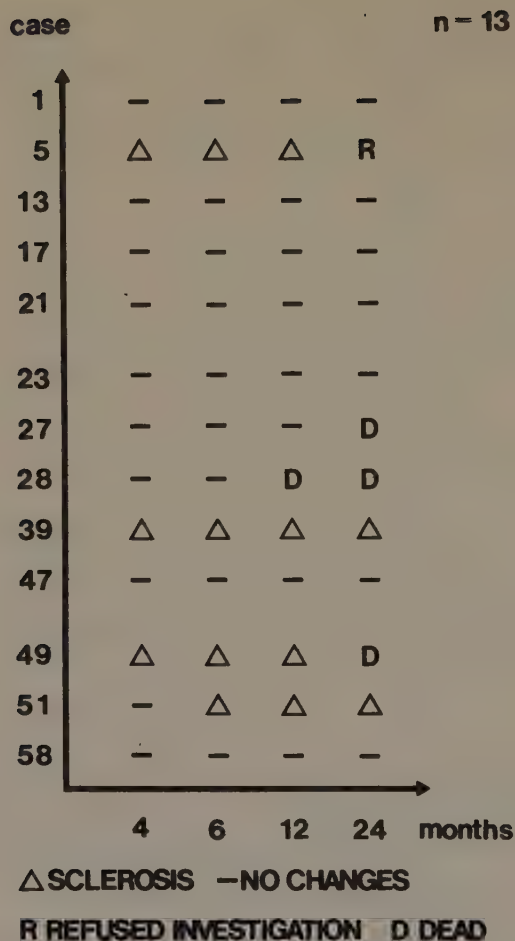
Radiographic changes in the femoral head in 13 cases with uncomplicated healing
